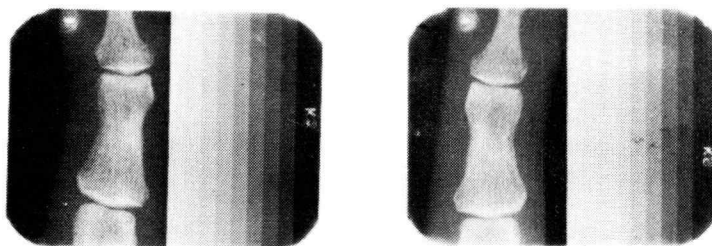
Typical X-ray of Adult Phalanx 5-2, Right and Left Hands.
